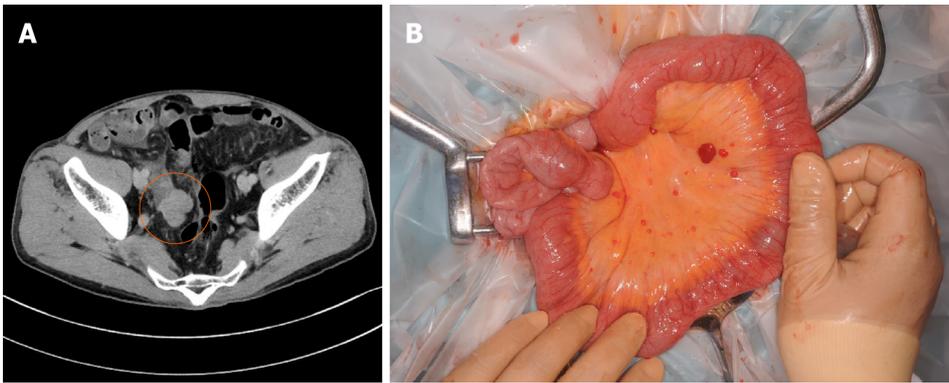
Abdominal contrast-enhanced computed tomography before the third surgery and the intraoperative findings. A: Abdominal contrast-enhanced computed tomography showed a tumor 32 mm in diameter in the pelvis (orange circle); B: Many small peritoneal nodules were found at the time of laparotomy.
